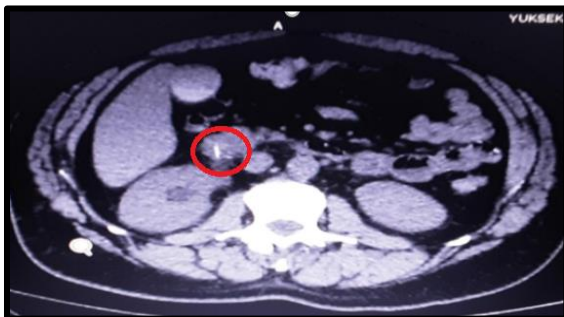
CT image. The foreign body appears in the 3rd part of the duodenum.
